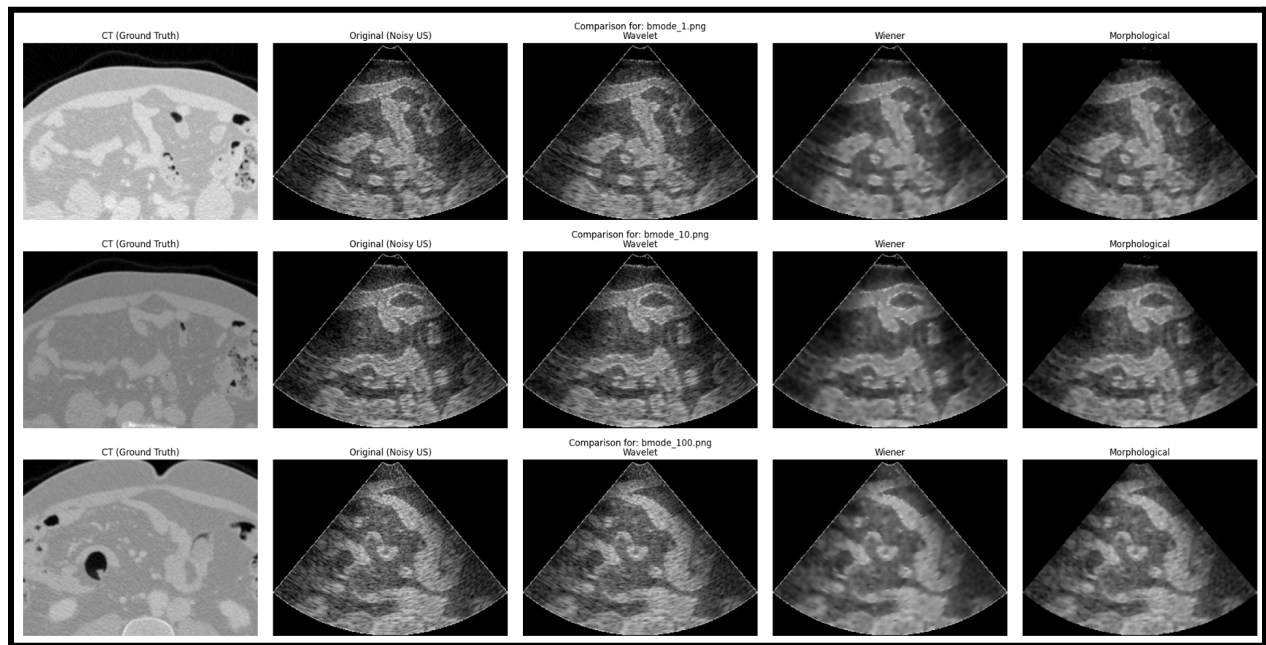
Figure #3: Side-by-Side Images for CT, Original & Denoised Ultrasound.
